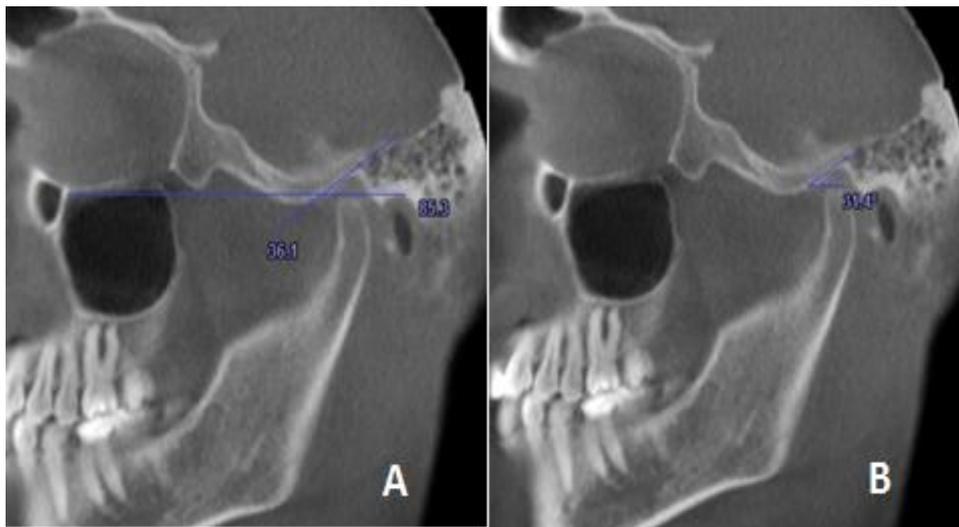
A and B. Determination of condylar guidance by CBCT
